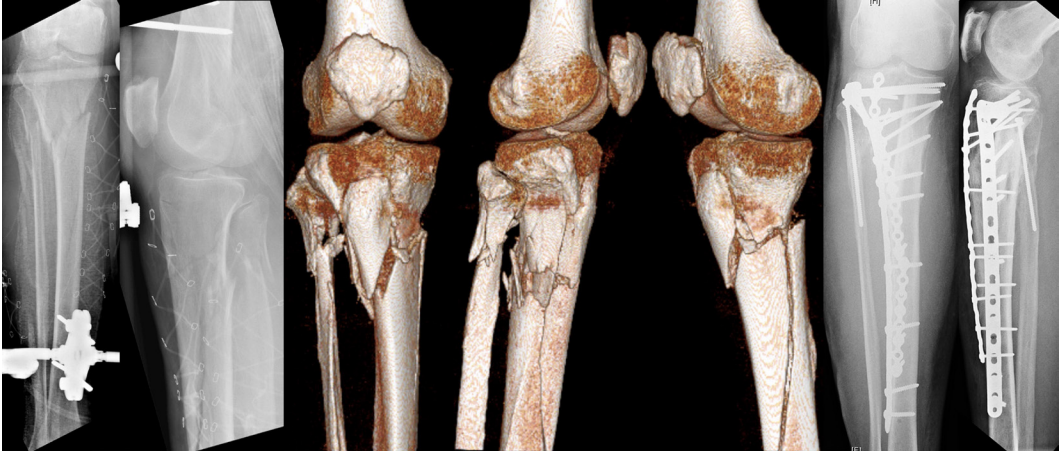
65-year-old male who suffered a closed 41C-2 proximal tibial fracture treated with this novel construct. Injury radiograph (left), 3D CT reconstructions (middle), and 12-month radiographs (right).
